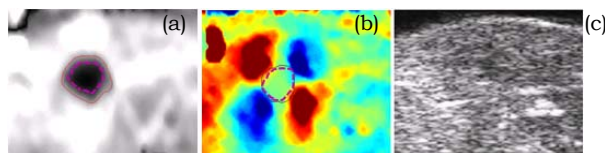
(a) ASE, (b) ASSE and (c) sonogram of a HIFU-induced lesion. The iso-intensity contour lines are overlaid on the elastograms for the threshold values; -2dB (-) and -6dB (--).
